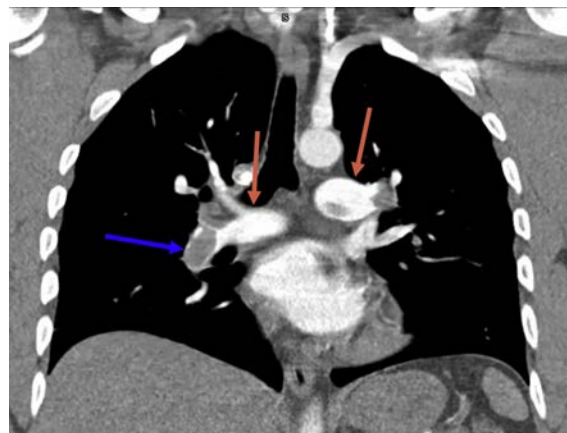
Coronal CT angiography demonstrating dilated pulmonary arteries (Fleischner sign; orange arrows) with abrupt vessel cutoff of the right lower lobe pulmonary artery (knuckle sign; blue arrow), corresponding to findings in Figure 1.
